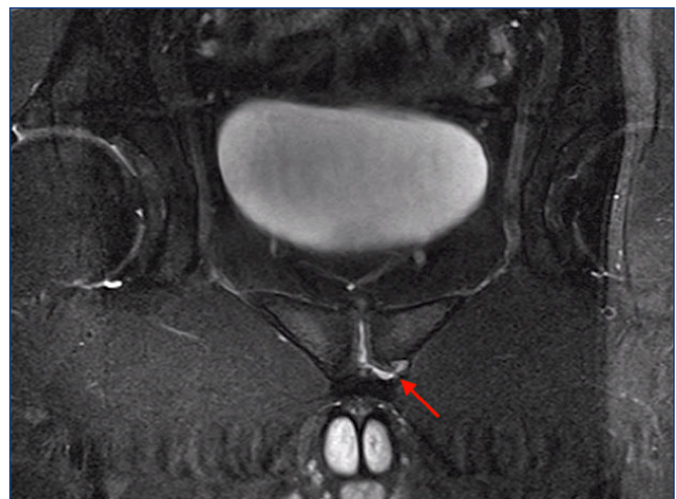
T2 axial oblique MRI demonstrating tearing of the rectus abdominis from the pubic tubercle.
